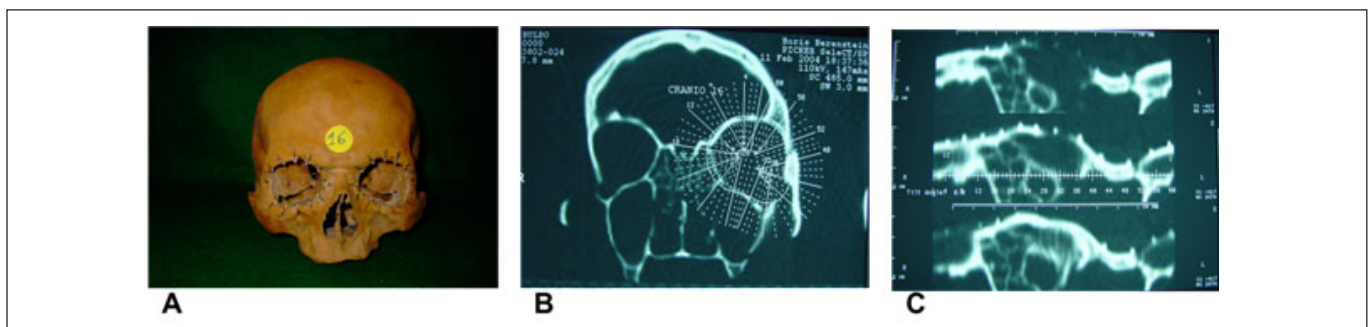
Skull and computed tomography scan of the left orbit. A - Skull with the demarcated right and left peri-orbital regions; radiopaque points determined in accordance with the marking provided by the locator; B - location and delineation of the anatomical points; C - scale showing the sequence of reconstructions (from 1 to 60) with the respective correspondence of the radiopaque images of the repair points fixed in each skull.
